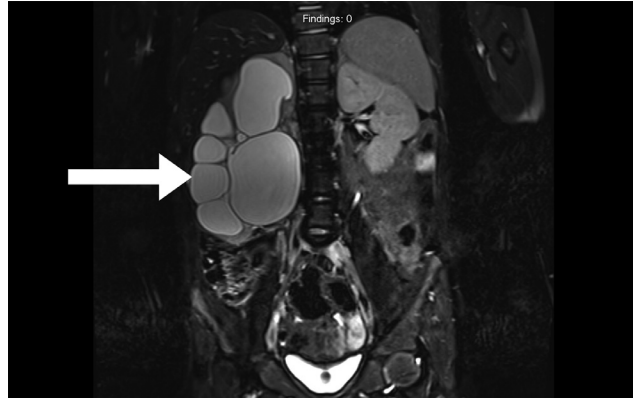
T2-weighted magnetic resonance imaging urogram demonstrating severe hydronephrosis. Arrow denotes the dilated collecting system as seen in severe hydronephrosis.
